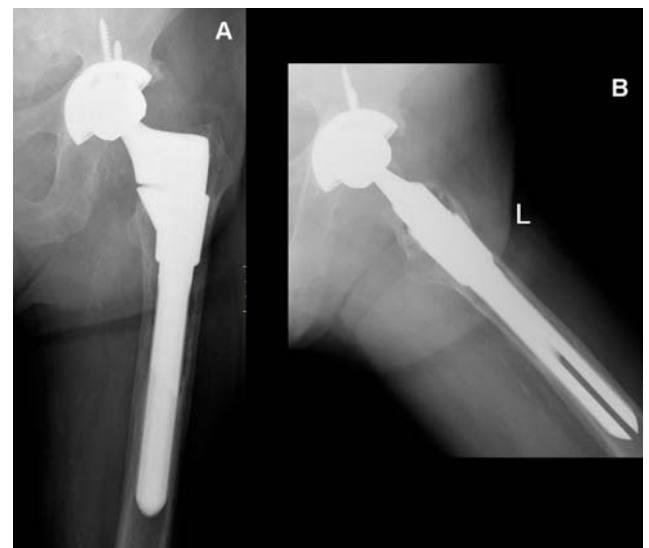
Posteroanterior (A) and axial (B) view x-ray imaging of pelvis showing left cementless modular revision arthroplasty after 3 years of follow-up.
